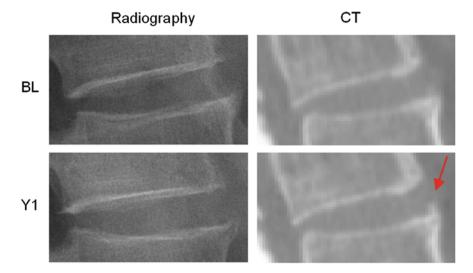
Example of syndesmophyte growth from baseline (BL) to year 1 (YI) visible on CT reformations but not on radiographs
